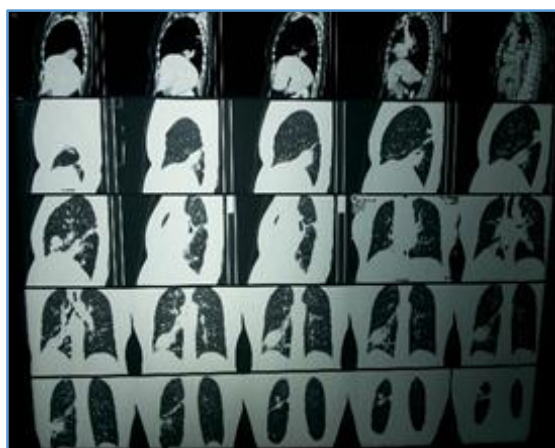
CT Chest before Starting Treatment
